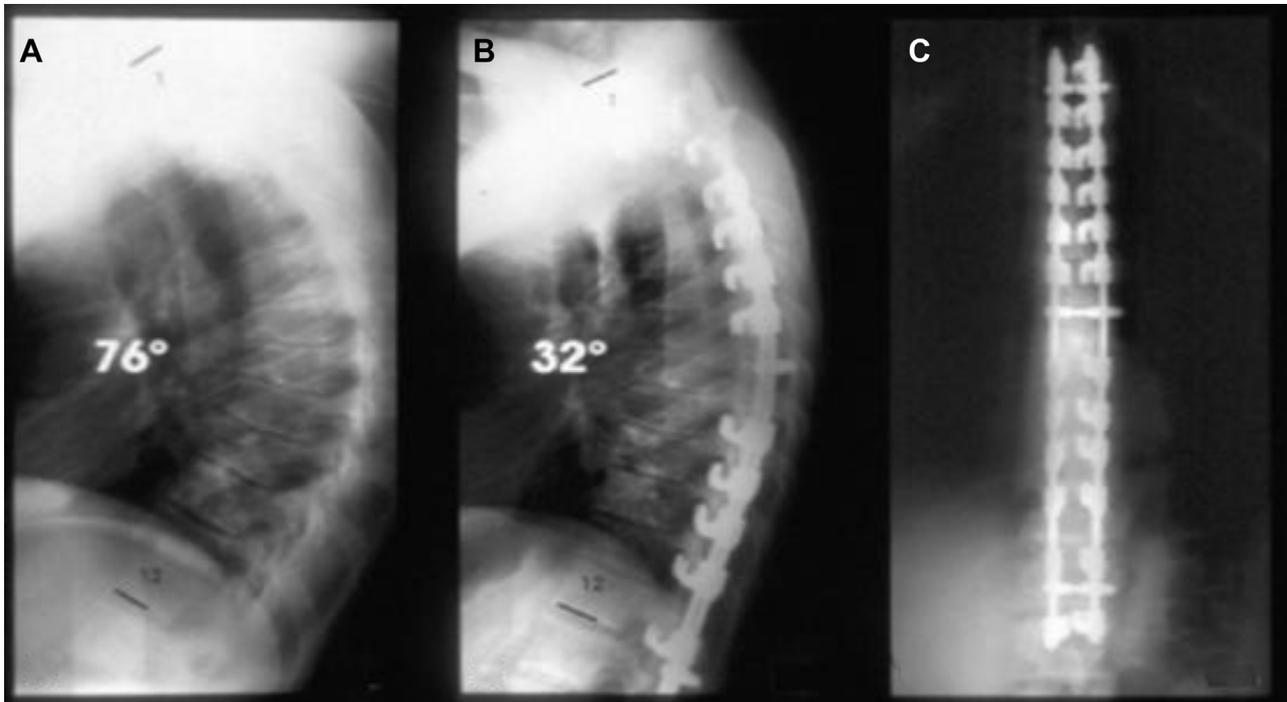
A 29-year-old male patient with Scheuermann kyphosis. (A) Preoperative standing lateral radiograph showing a 76° kyphosis. Surgery consisted of 12 levels of Ponte osteotomy, instrumentation, and fusion from T1 to L1 with 24 laminar hooks and a 4.8-mm semirigid rod compression construct. (B) Standing lateral radiograph 32 months after surgery showing a correction to 32°. (C) Standing AP radiograph showing the fully segmental construct, extending from T1 to L1 (No long radiographs then). AP, anteroposterior.
